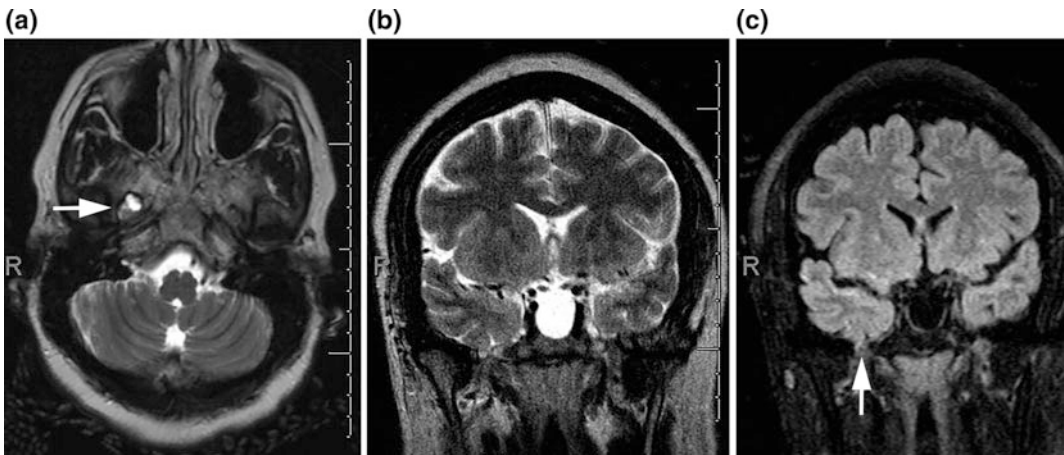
Axial and coronal T2-weighted MRI, and coronal FLAIR demonstrate a small encephalocele that involves a focal portion of the fusiform gyrus cortex extending into the right foramen ovale (arrows). The MRI
